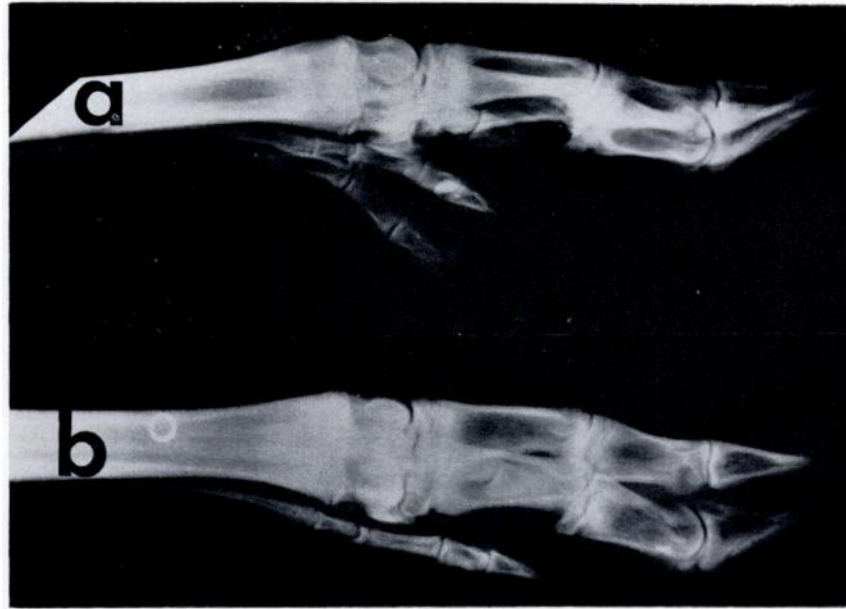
Radiograph of the right front foot from two female white-tailed deer fawns: (a) polydactylous foot with five complete digits, showing the phalanges of the supernumerary digit and the extra unfused metacarpal bone, Ontario, 1967; (b) normal foot with four digits, Ontario, 1968.
